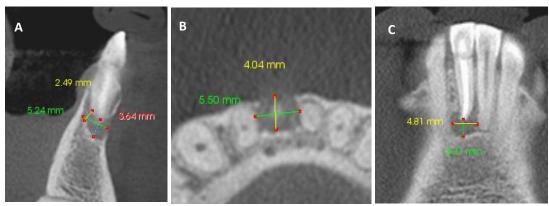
CBCT - PAI 4 +D (destruction), which was the most frequent lesion size. A. Measurements obtained from the saqittal slice; B. Measurements obtained from the axial slice; C. Measurements obtained from the coronal slice.
